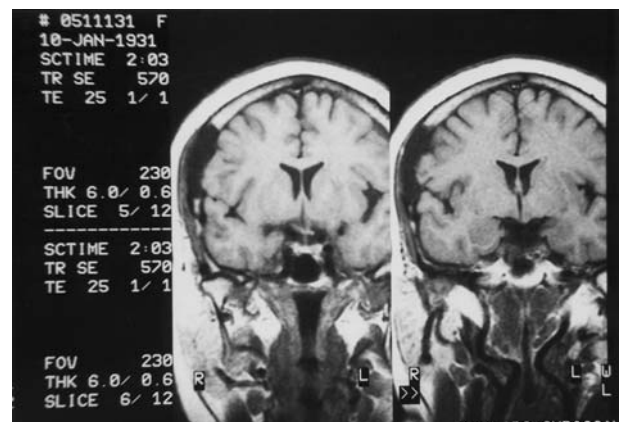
MRI coronal sections: iso-intense right frontotemporal lesion with CSF on T1 weighted images, the adjacent brain tissue was normal
